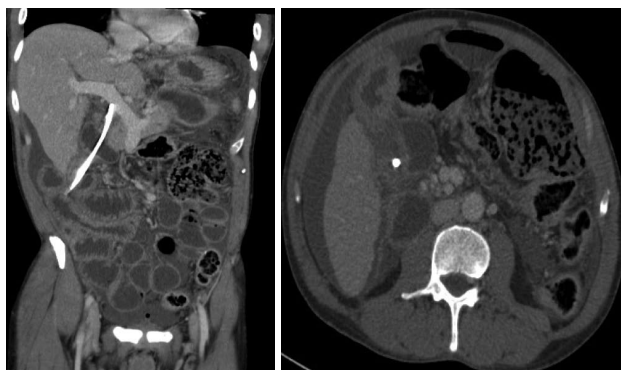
Computed tomography-scan of the abdomen which confirmed the inferior migration of the biliary stent causing perforation of the second part of duodenum, with protrusion of the stent into the peritoneal cavity causing biliary peritonitis.
